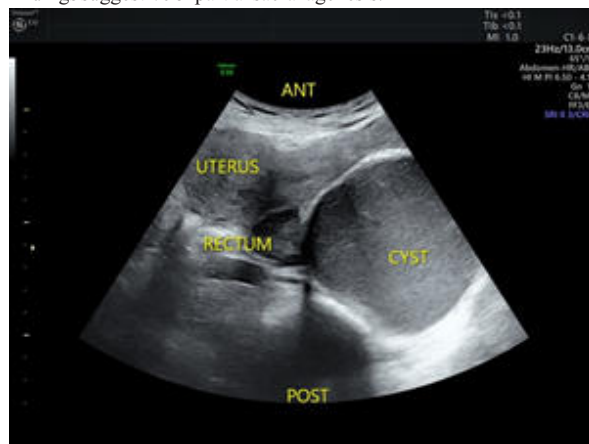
Ultrasound image of the pelvic area showing a thin-walled
